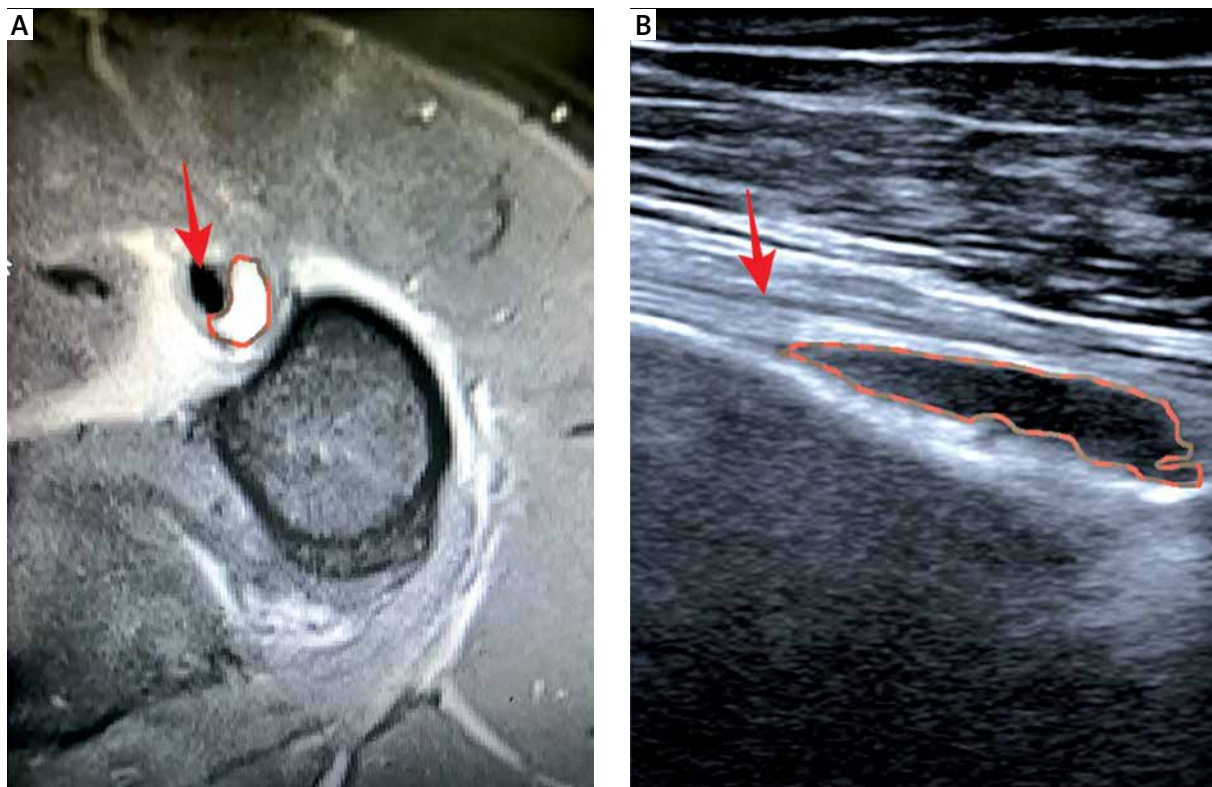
A – MRI transverse scan of the LHB (arrow) with accumulation of fluid inside the bicipital groove (orange line). B – US longitudinal scans of the LHB (arrow) with hypoechoic fluid below the tendon (orange line)
